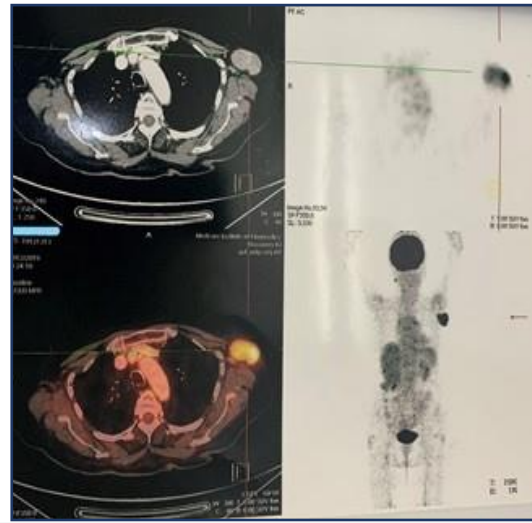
Whole body PET CT showed a large axillary nodal mass with nodules in the left lobe of the thyroid. Both breasts are normal.
